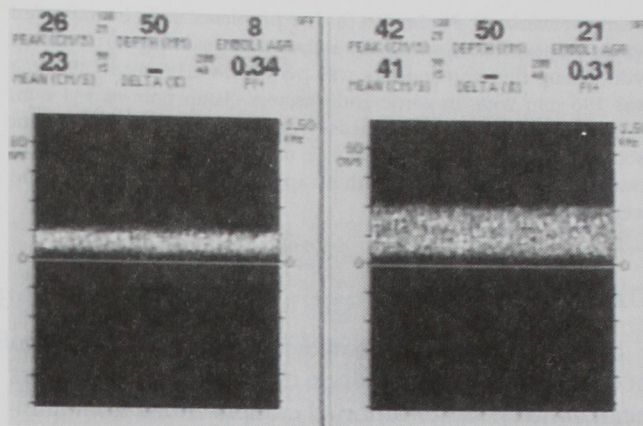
Transcranial Doppler image of right and left middle cerebral arteries showing asymmetric blood flow velocity. The peak and mean velocities in the right middle cerebral artery are substantially reduced compared with the left caused by a reduction in perfusion as a result of the endovascular aortic balloon clamp partially occluding the innominate artery.
